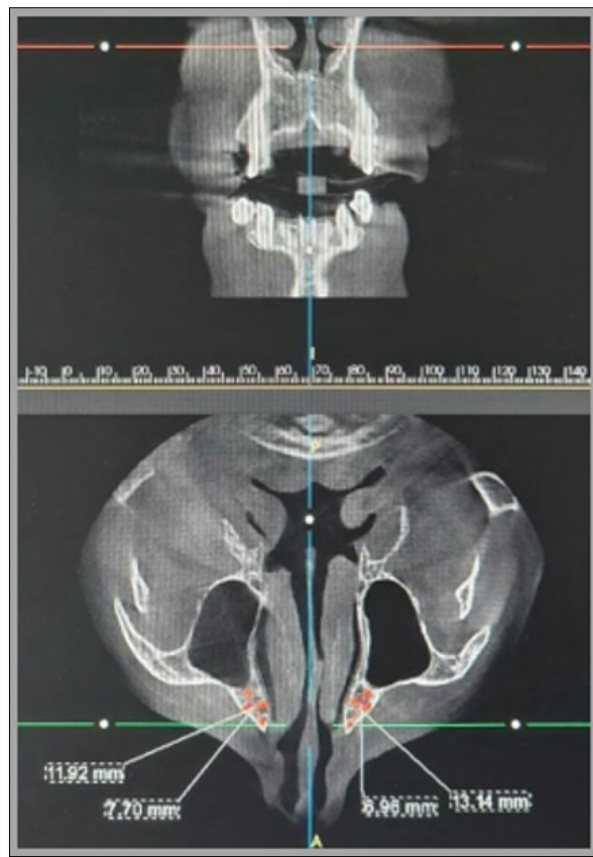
CBCT assessment of the anterior nasal region.
